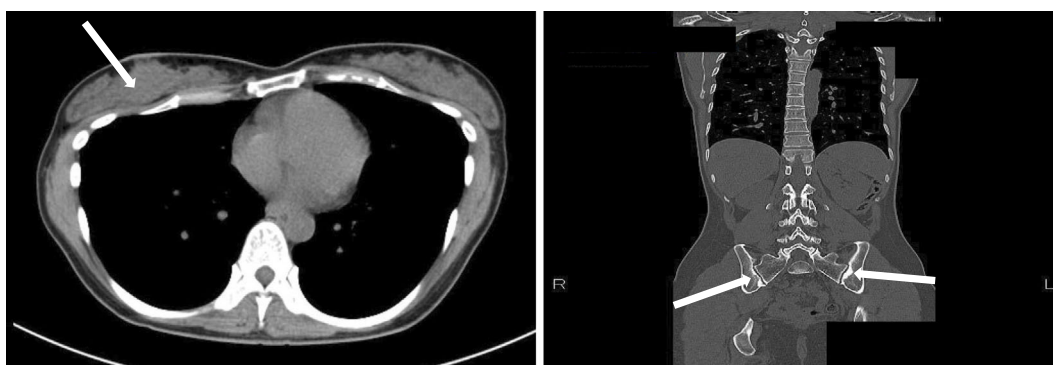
Computed tomography scans. Left: A deformity of the right chest wall (arrow). Right: bilateral calcification of sacroiliac joints (arrow).
